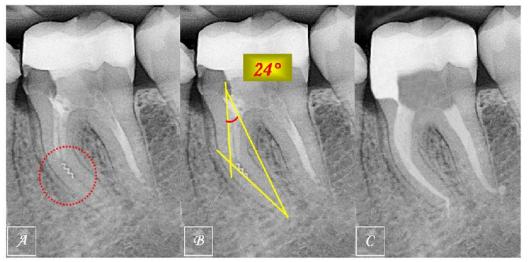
A/separated 3mm's fragment of endodontic instrument - a lentulo, on tooth 46; B/analysis and measurement of angle curvature and radius of curvature; C/ Postoperative x-ray - definitive obturation of root canals and elimination of separated fragment.
